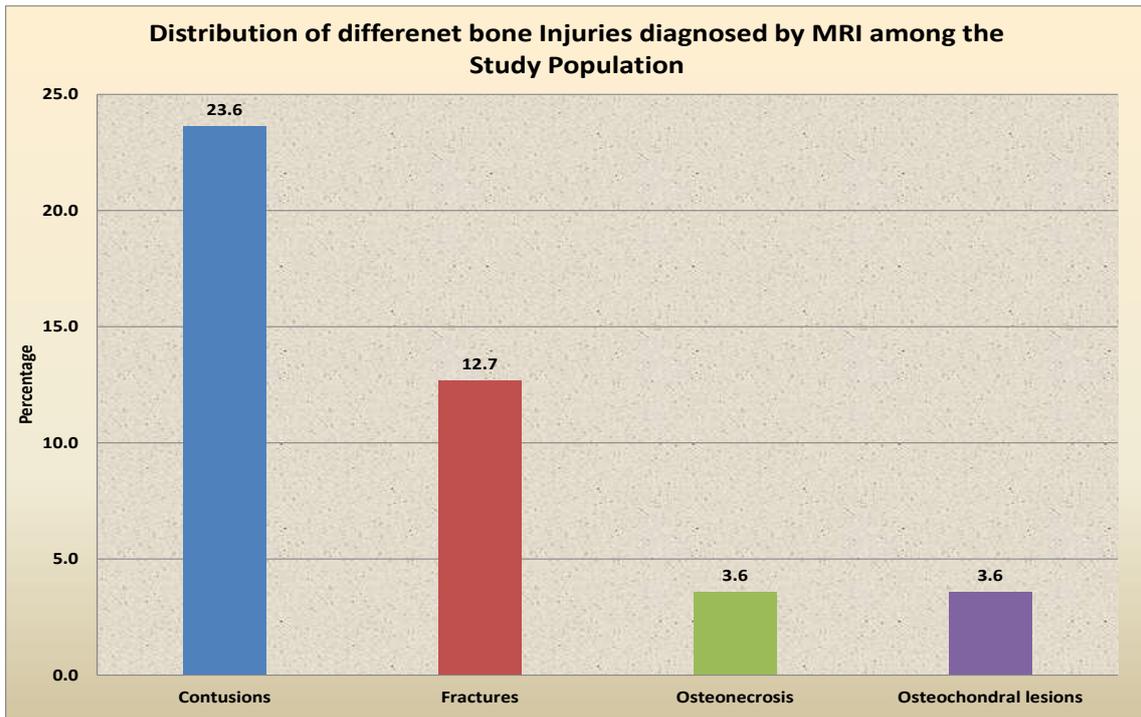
Chart depicting different Bone injuries diagnosed by MRI.
